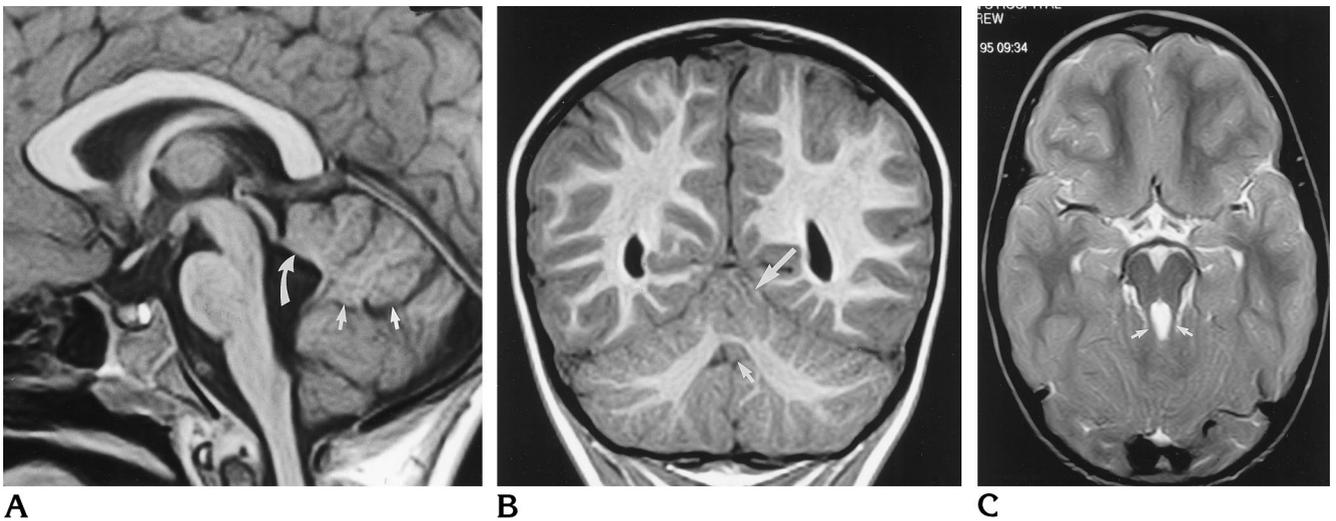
Case 1: Small inferior portion of the vermis in a 4-year-old boy with partial congenital ocular motor apraxia who presented initially with head titubation and nystagmus at 5 days of age. CT scan at 1 month (not shown) was interpreted as normal.
